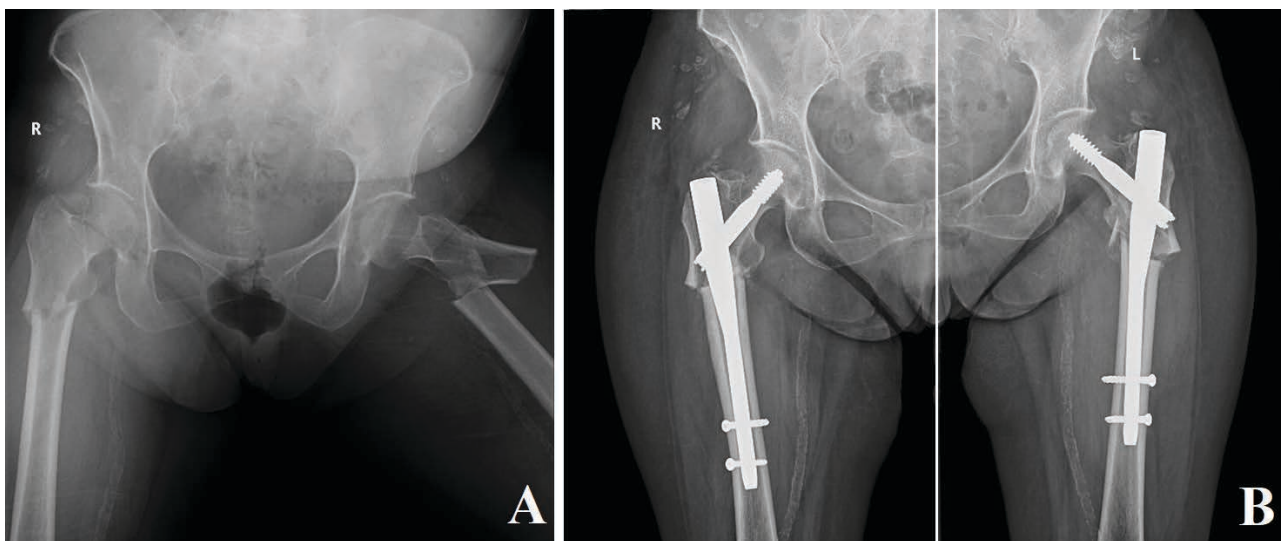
Bilateral subtrochanteric fracture secondary to BPs therapy. (A) Preoperative aspect – X-ray view (anteroposterior incidence), (B) Postoperative aspect – gamma nail
